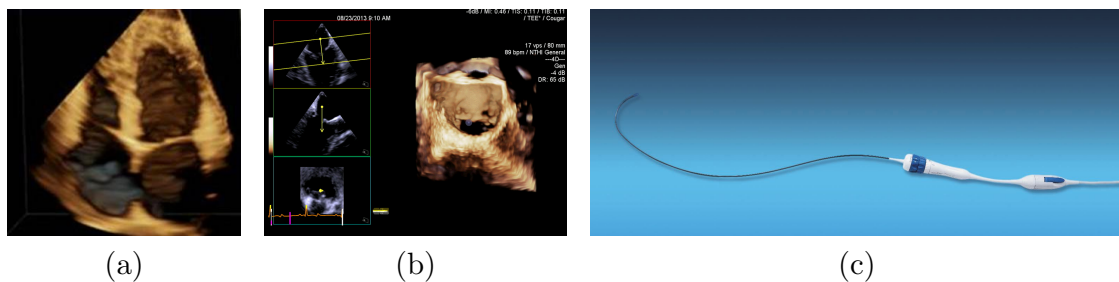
(a) Transthoracic Echocardiogram (TTE) showing four-chamber view of the heart; (b) Volumetric TEE image of the mitral valve opening, and reformatted 2D slices through the anatomy; (c) Siemens AcuNav V volumetric ICE catheter with steering handle
